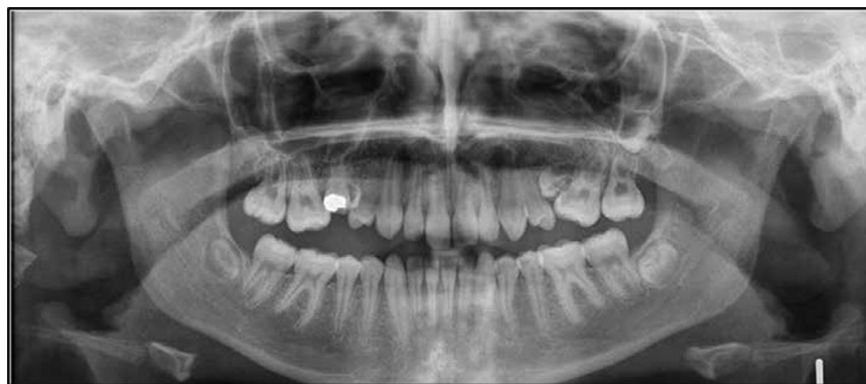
Orthopantomogram showing infraoccluded upper second deciduous molars.
